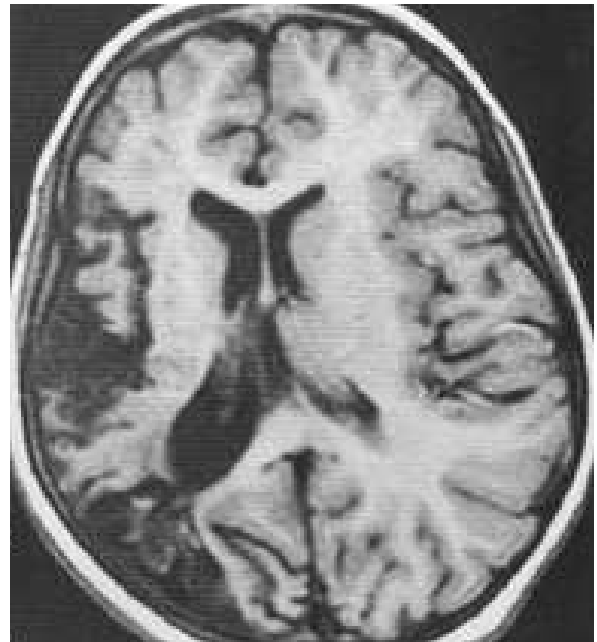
MRI showing brain Infarcts
